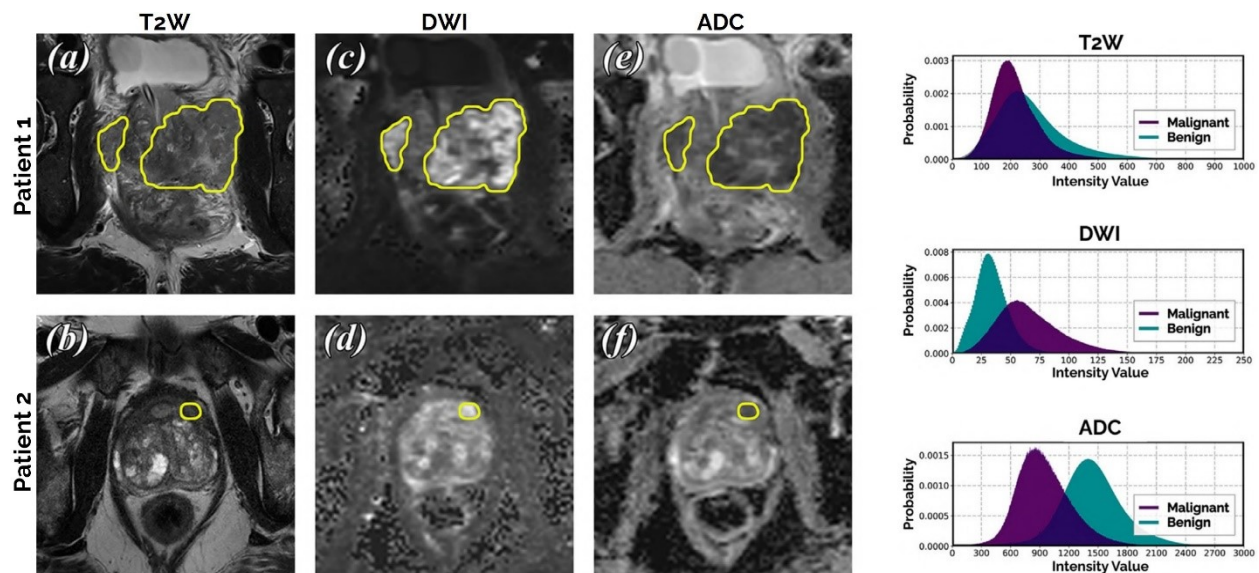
example of tumors in the same section as seen in MRI with different parameters (mpMRI): a) T2 Anatomic MRI, b) DWI diffusion weighted MRI, c) ADC apparent diffusion map MRI.
